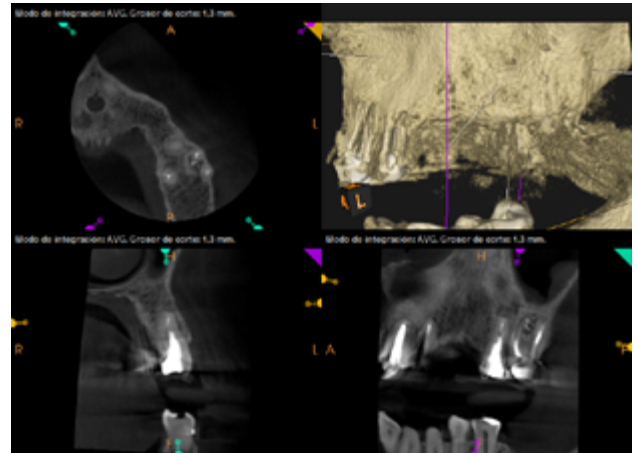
Control tomographic image at the level of 15, 12 months after periapical microsurgery in which the resolution of the pre-existing periapical radiolucent lesion can be seen.
